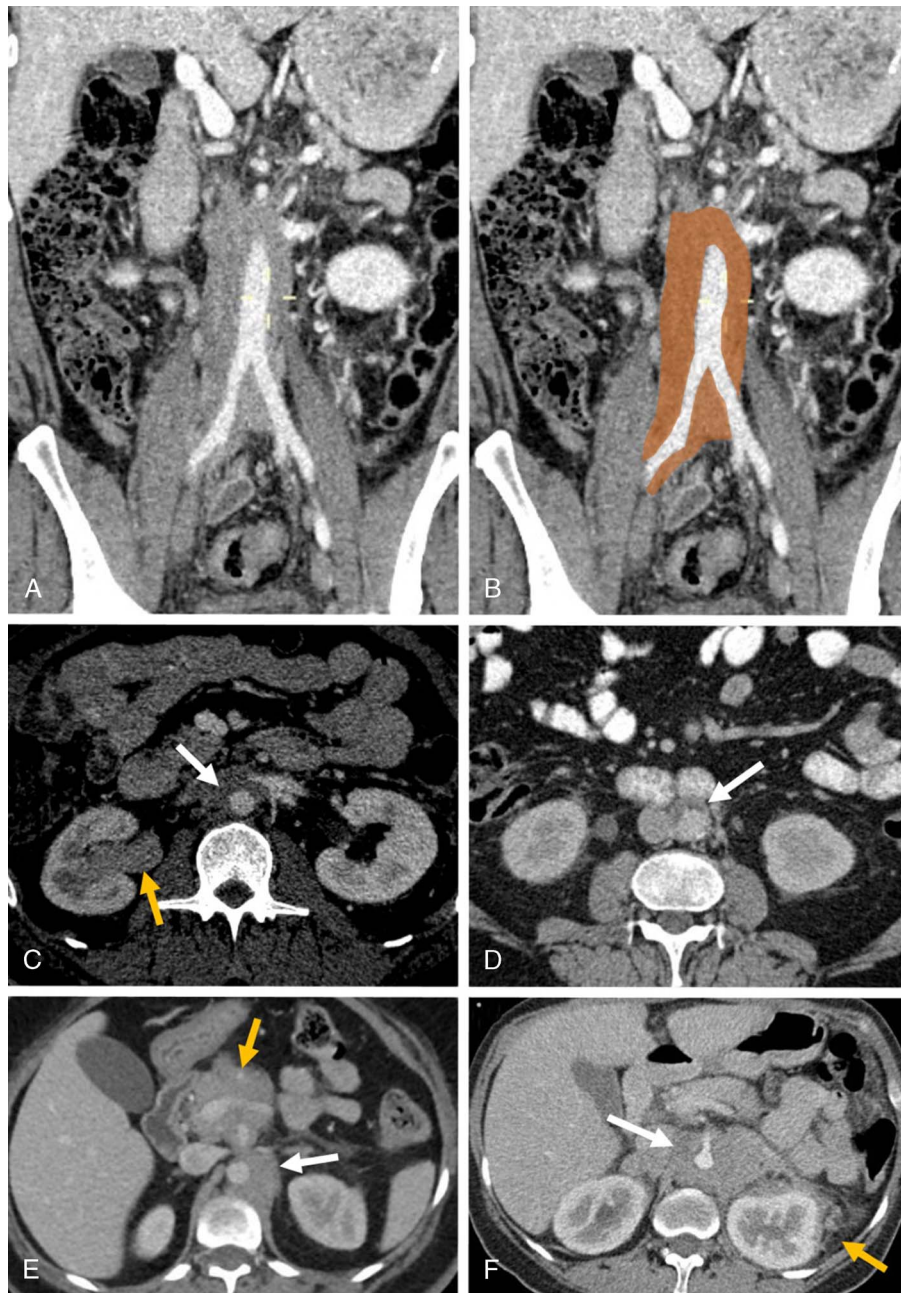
A and B, Contrast-enhanced coronal CT images showing retroperitoneal tissue adjacent to the infrarenal abdominal aorta and iliac arteries (orange shadow) in a 56-year-old man presenting with abdominal pain, weight loss, and elevation of inflammatory markers. C, Axial CT image from the same patient showing retroperitoneal tissue (arrow) that encases the abdominal aorta lateral and anteriorly and the right ureter, leading to pyelectasis (yellow arrow); serology and biopsy confirmed IgG4-RPF. D, Axial CT image showing retroperitoneal tissue (arrow) that encases the abdominal aorta lateral and anteriorly in a patient with IRPF. E, Contrast-enhanced axial CT image of the abdomen shows left para-aortic retroperitoneal tissue with anterior displacement of the aorta (white arrow) in a 54-year-old woman with follicular lymphoma; a mass at the mesenteric root is also shown (yellow arrow). F, Contrast-enhanced axial CT image of the abdomen shows a “coated aorta” appearance (white arrow) and left “hairy kidney” in a 46-year-old man with Erdheim-Chester disease. Color online-figure is available at <http://www.jclinrheum.com>.
